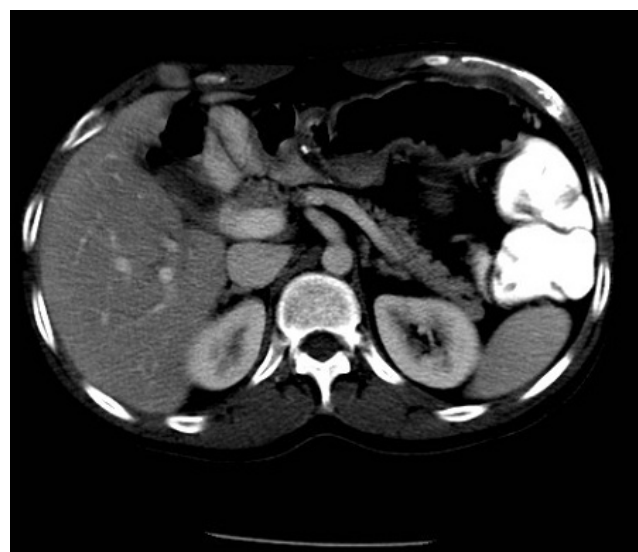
Follow up CT scan of abdomen 2 years after surgery showing no abnormality.
